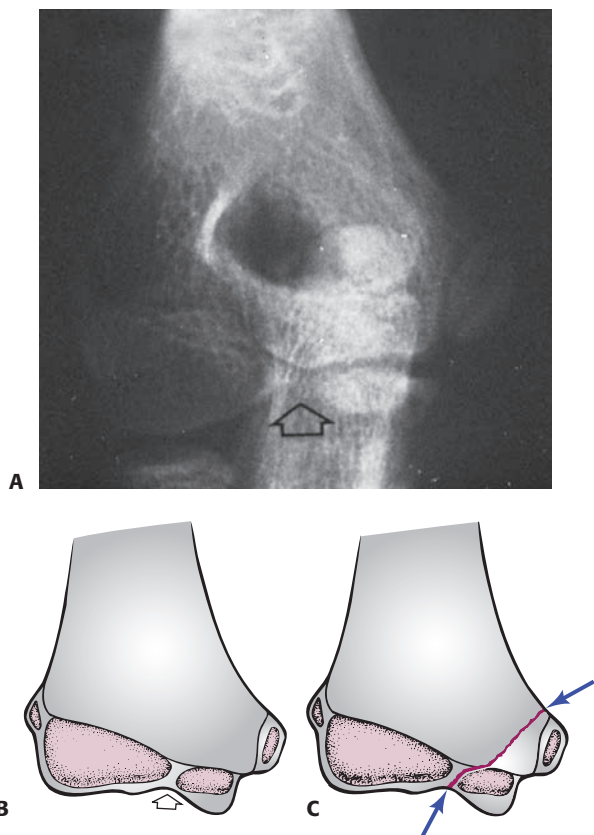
A: The AP radiograph of a 9-year-old boy demonstrates the location of the ossification centers. A common physal line (*arrow*) separates the medial and lateral condylar physes. B: Relationship of the ossification centers to the articular surface. The common physis terminates in the trochlear notch (*arrow*). C: Location of the usual fracture line involving the medial condylar physis (*arrows*).
